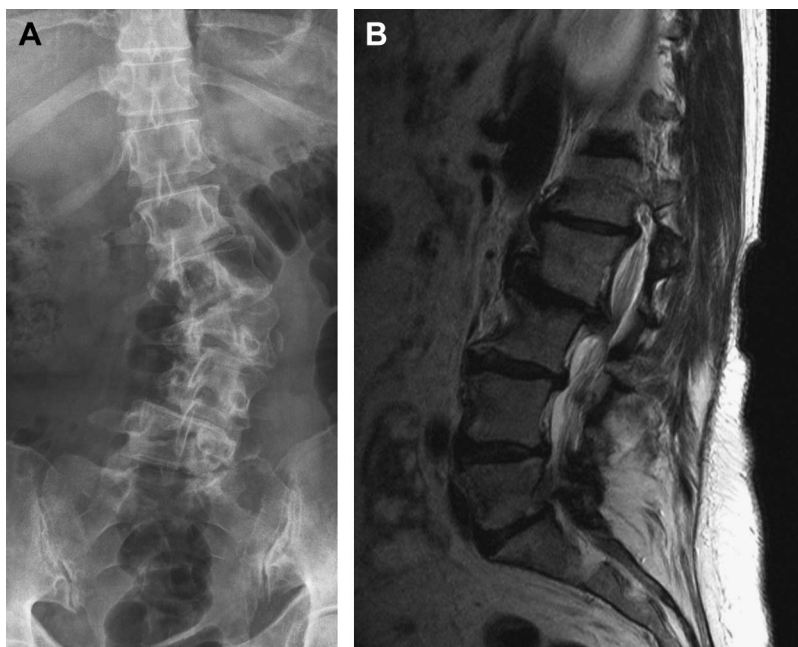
A, An anteroposterior x-ray of the lumbar spine of patient 1 showed a lumbar torsion scoliosis with a Cobbs angle of 48°. (B) MRI scanning showed discopathy at all lumbar levels, with loss of height at L2-L3 and L3-L4. At level L1-L2 left and L2-L3, a right subforaminal herniation with spondylosis can be seen with caudal impression and bulging at level L3-L4. This lumbar pathology resulted in a severe motor impairment of the legs.
